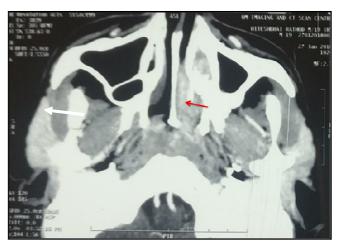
Axial contrast enhanced soft window CT scan showing intense heterogeneously enhancing (*red arrow*) in left nasal cavity extending into nasopharynx on left side. Also note enhancing lesion in expanded left bony nasolacrimal duct.
